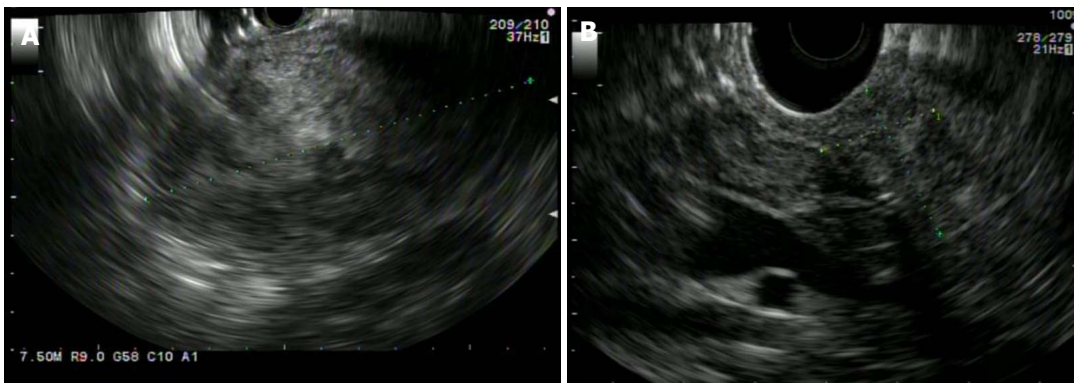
Endoscopic ultrasound appearances. A: SPN adjacent to the gastric wall. SPN demonstrates heterogenous echogenicity on EUS, with hyperechoic foci representing solid areas with surrounding hypoechoic cystic spaces; B: A pancreatic head SPN. EUS: Endoscopic ultrasound; SPN: Solid pseudopapillary neoplasm.
